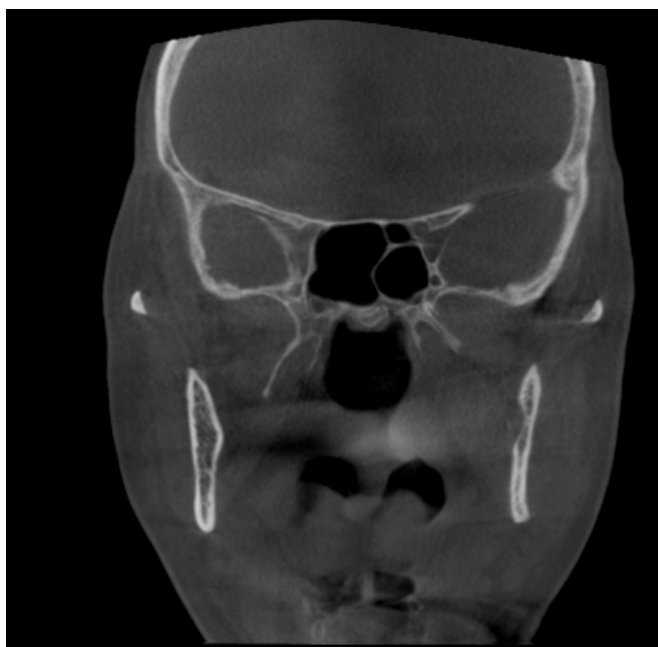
Onodi cell on coronal CBCT section
